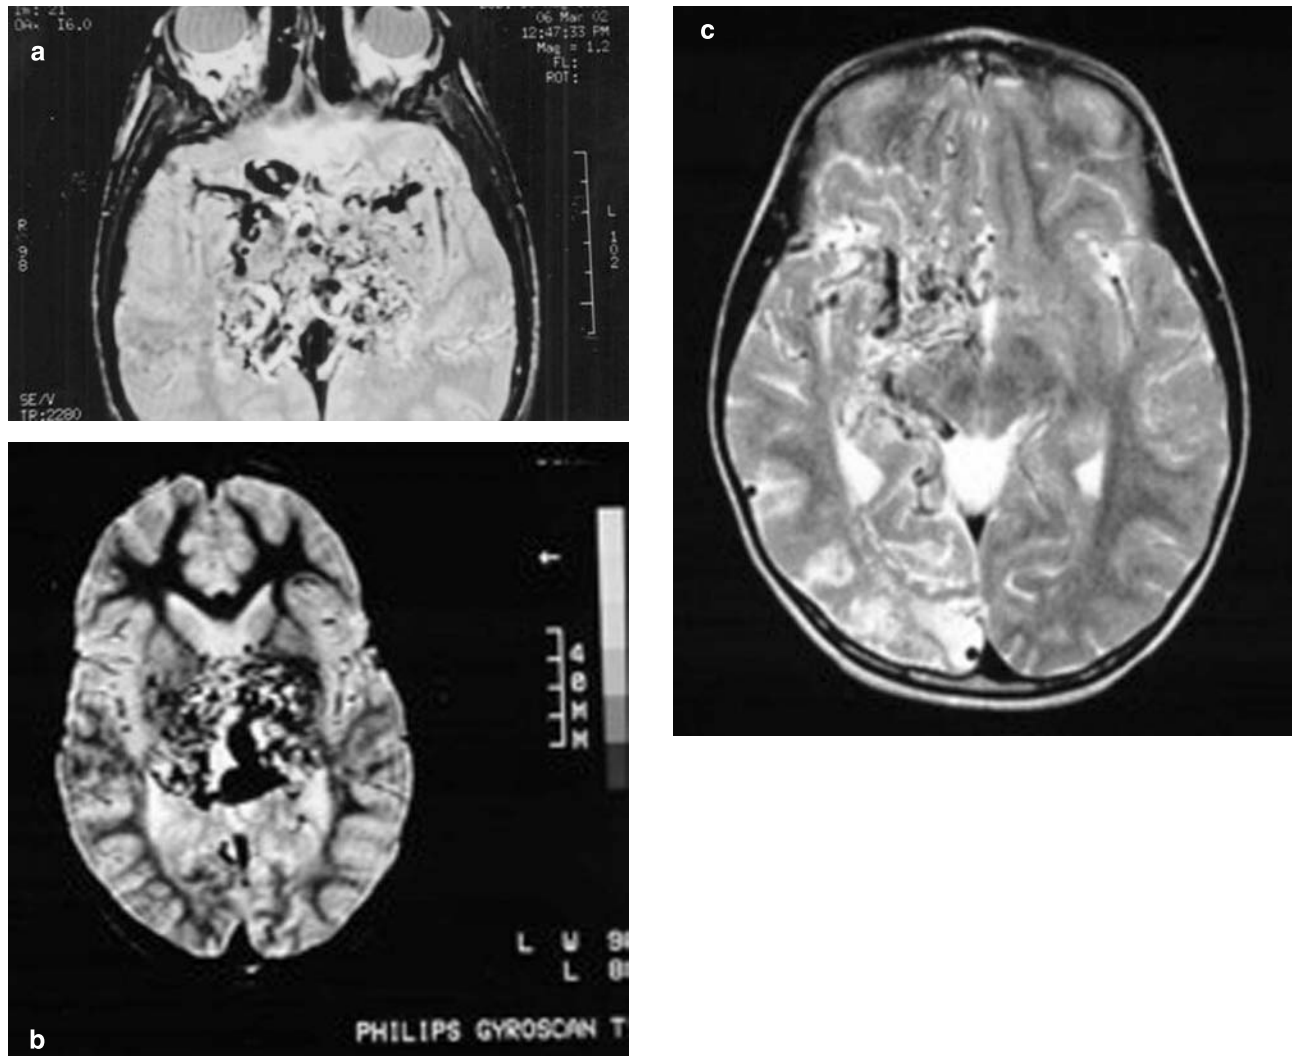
Axial T1-weighted (a–b) and T2-weighted (c) magnetic resonance images of the brain showing typical vascular malformations: deeply located in the midbrain and brainstem (a) in a woman who had acute headache as presenting symptom at age 22 years; (b) deeply located in the entire thalami and basal ganglia regions in a 44-year-old woman who had hemiparesis at onset; (c) located in the entire right hemisphere with high signal areas in the posterior regions in a 6-year-old child (same child shown in Fig. 1) who had headache and later progressive cognitive deterioration (Figs. a and b are courtesy of Professor G. Pero, Institute of Neuroradiology, University of Catania, Italy).
